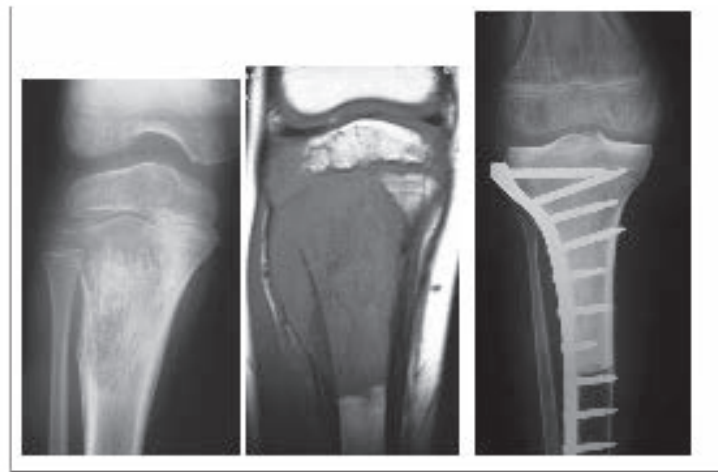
Proximal tibia Ewing sarcoma in a 10 years old boy. *A*): A-P radiographic view of the tumour before neoadjuvant chemotherapy; *B*): Coronal view of preoperative MRI showing epiphyseal involvement; *C*): Postoperative radiograph showing osteoarticular allograft reconstruction with periarticular plate osteosynthesis.
